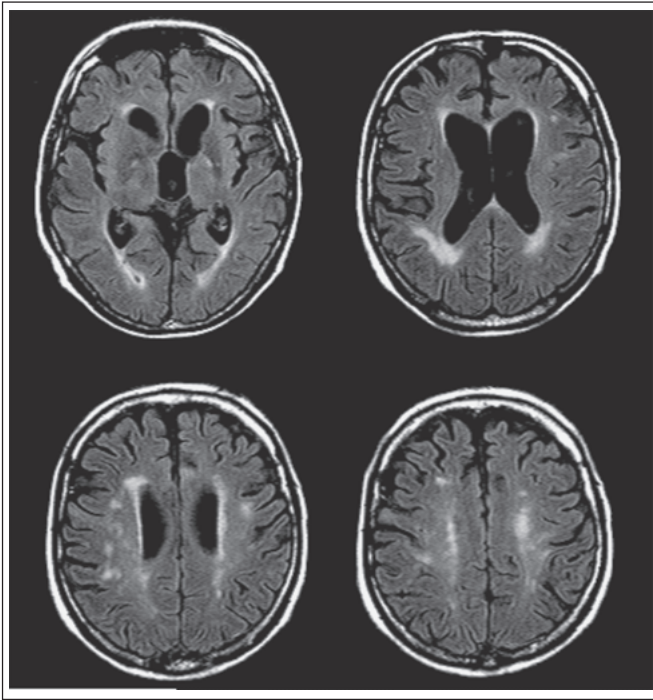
Cerebral MRI (FLAIR) of a 35-year-old male, treated with MTX-based chemotherapy and whole-brain irradiation at the age of 20: ongoing complete response of a high-grade malignant Non-Hodgkin's B-cell lymphoma. Cognitive dysfunction due to leukoencephalopathy and deep-brain atrophy.
